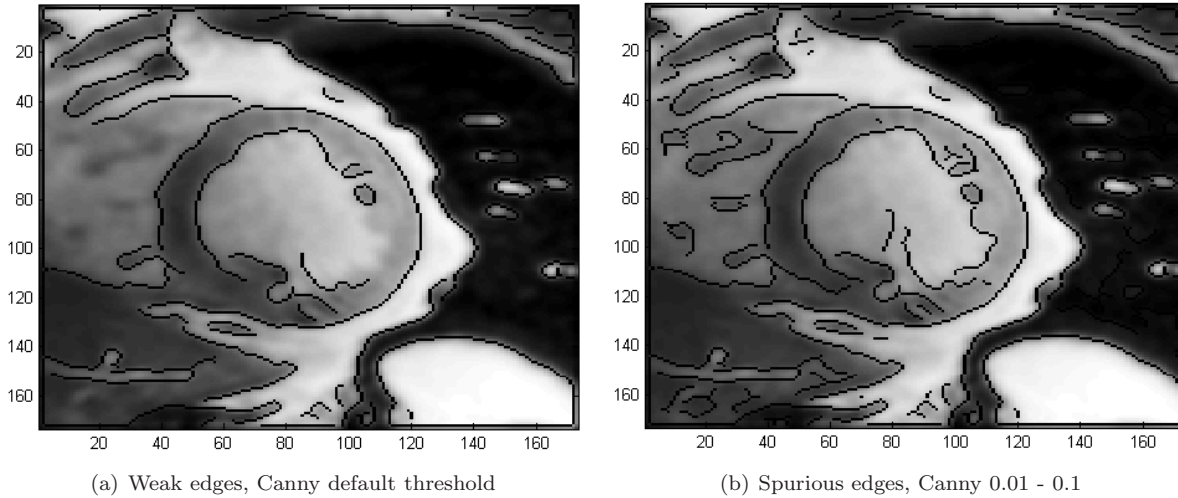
Weak edges in cine-MR images using Canny edge-detector. The dark lines represent the edges over the original image.
